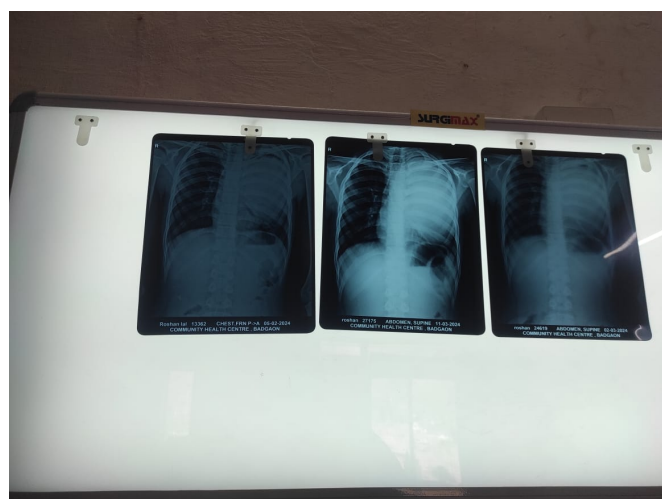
Cxray - well-circumscribed homogeneous rounded opacity is seen in the left mid-zone, which corresponds to the location seen in the CT scan—suggestive of a pulmonary hydatid cyst
